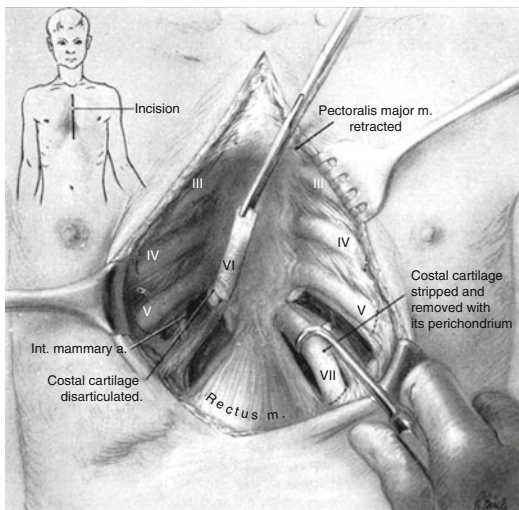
The midline incision from manubrium to epigastrium. Here, the pectoral muscles are stripped back allowing for bilateral parasternal and subperichondrial resection of the deformed costal cartilages [2]
